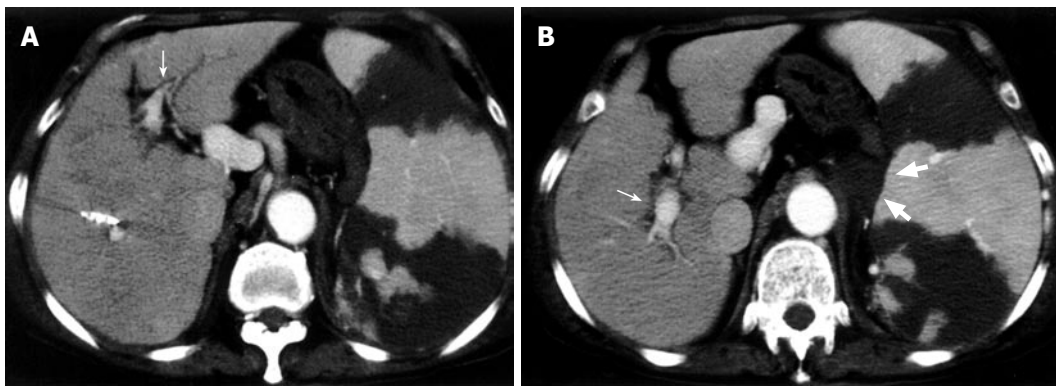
Contrast-enhanced CT 1 wk after catheter-directed thrombolysis and BROTO. A: Good patency of the portal vein (narrow arrow); B: Thrombosed splenorenal shunt (thick arrow).
